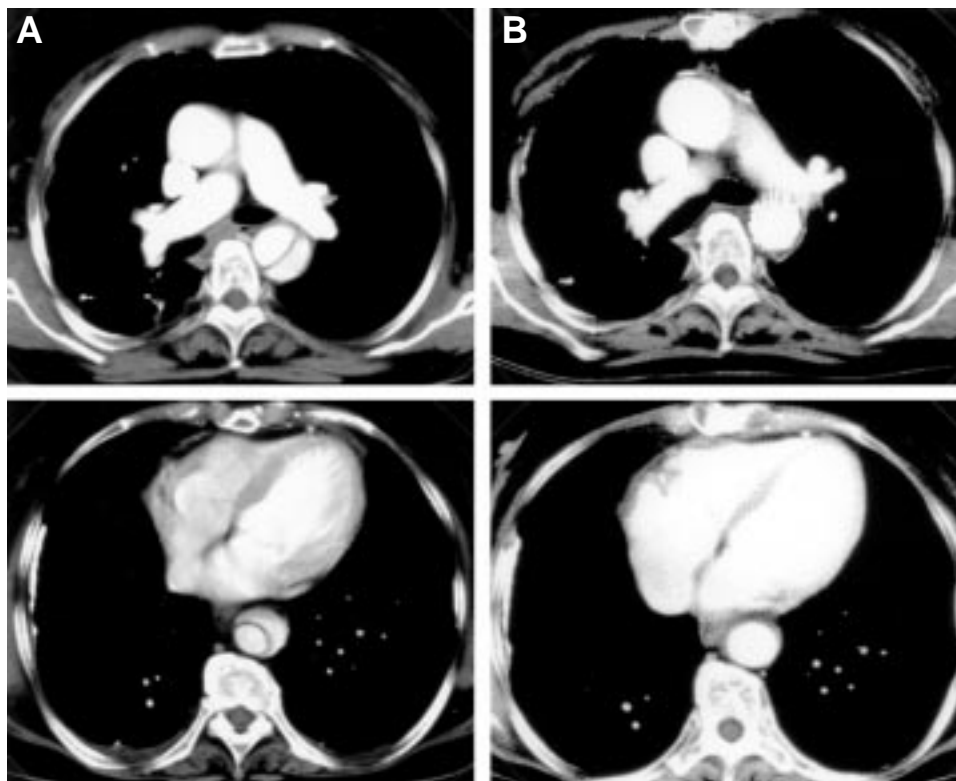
Contrast-enhanced computed tomography scans. A, Preoperative contrast-enhanced computed tomography scans demonstrated aortic dissection in the descending aorta. B, Contrast-enhanced computed tomography scans after the stent-graft repair showed complete elimination of the false lumen through the descending aorta.
